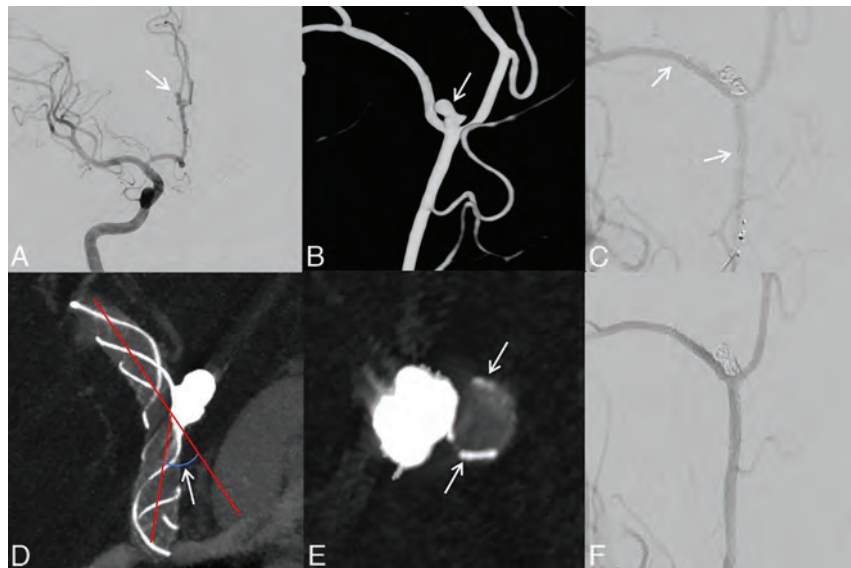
Use of the LVIS Jr stent in SAC for the treatment of an unruptured A2-segment aneurysm. A and B, 2D DSA and 3D DSA of the right ICA show an A2-segment aneurysm of the right anterior cerebral artery, with an irregular shape and a size of 1.5×2.7 mm. The parent artery diameter is 1.79 mm, and the diameter mismatch ratio is 1.15 (aneurysm is shown by a white arrow). C, SAC using a LVIS Jr stent (2.5×13 mm) was performed, and the aneurysm occlusion attenuation was Raymond-Roy class I (white arrows indicate the ends of the stent). D, HR-CBCT with diluted contrast media shows that the stent was completely deployed and stent angles were 43.34° (the stent angles are indicated by a white arrow). E, HR-CBCT shows complete stent apposition at the aneurysm neck and the coils protected satisfactorily (stent wire at the aneurysm neck is indicated by white arrows). F, DSA follow-up at 6 months shows stent patency, and the aneurysm has healed well (Raymond-Roy class I).
